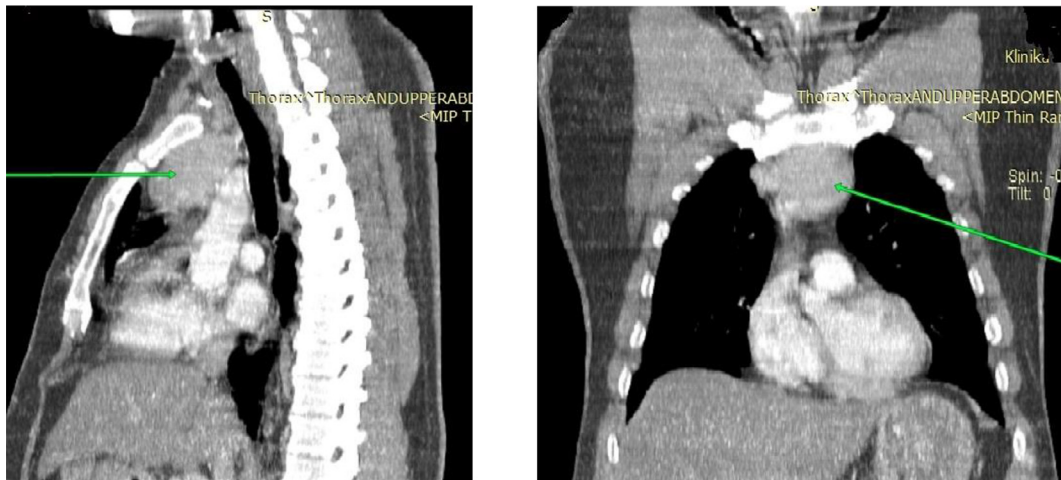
(a, b) Anterior mediastinal mass on contrast enhanced CT of the thorax (arrow) a. sagittal view, b. coronal view.
